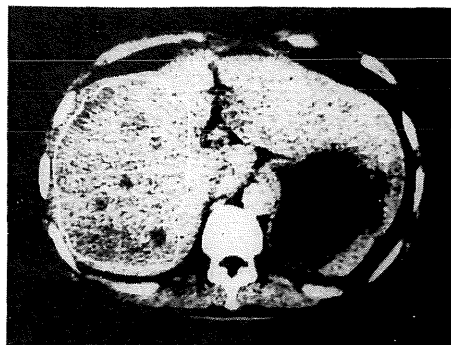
CT scanning of the liver showing multiple low-density areas in the right lobe.
